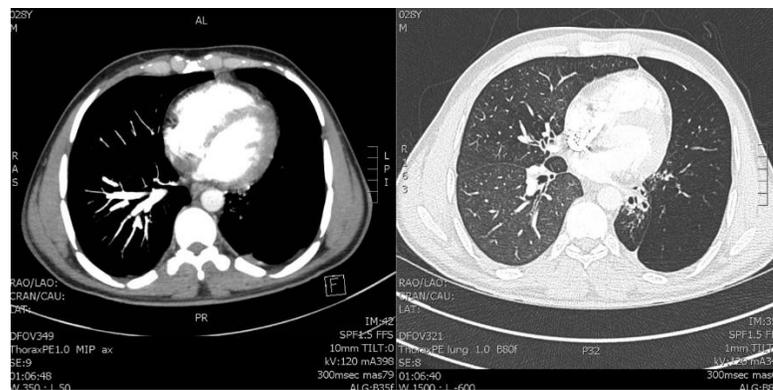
Chest CT (mediastinal windows) revealing parenchymal destruction and bronchiectasis; associated multifocal narrowing of the left lower lobe bronchus and paucity of left lower lobe segmental and subsegmental pulmonary vessels.
